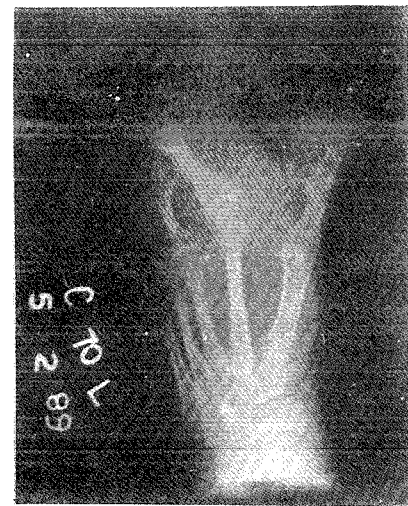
Xray of the affected foot showing increase in size of the bones of the affected toes as well as the corresponding metatarsal bones.
